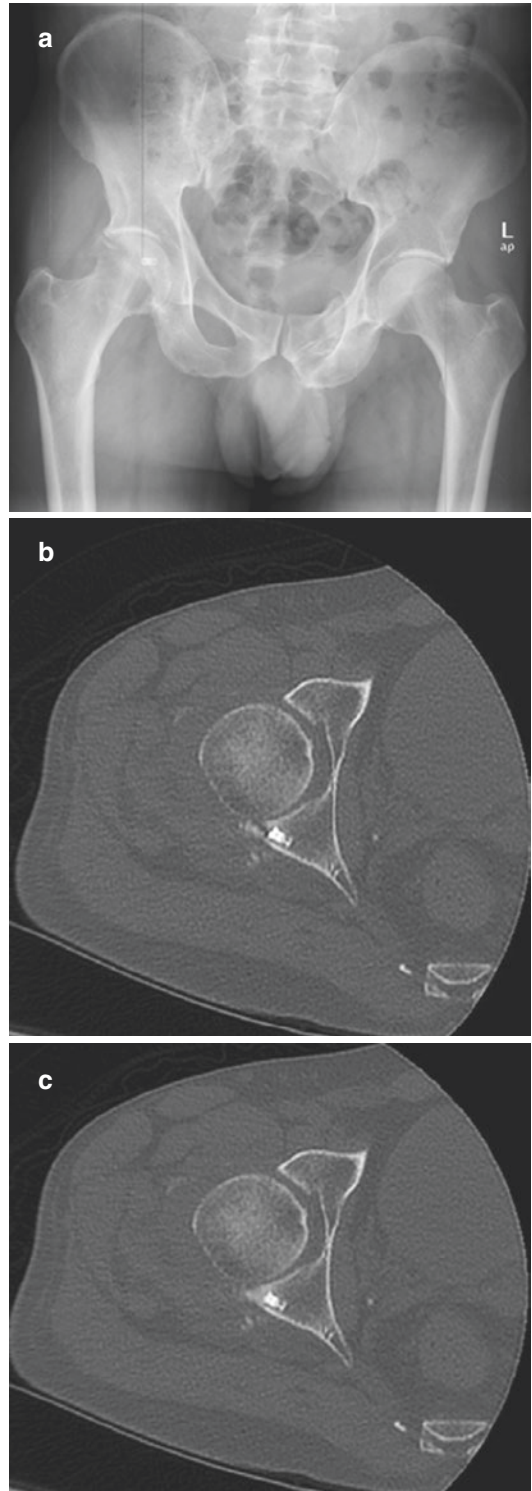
(a–c) Postoperative follow-up; X-ray and CT scan
